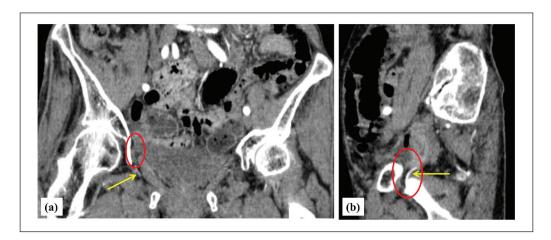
In the contrast-enhanced computed tomography, the red circle was hernia content, and the yellow arrow was the obturator artery. (a) A coronal view, and (b) A sagittal view showing a herniated viscera passing through the obturator hole.
